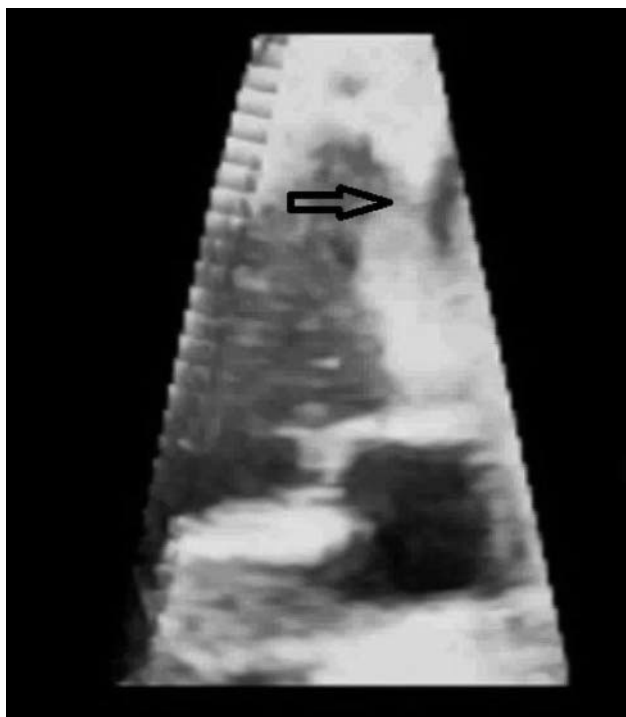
Sonogram obtained with a X6-1 xmatrix array transducer showing a small ventricular septal defect.
